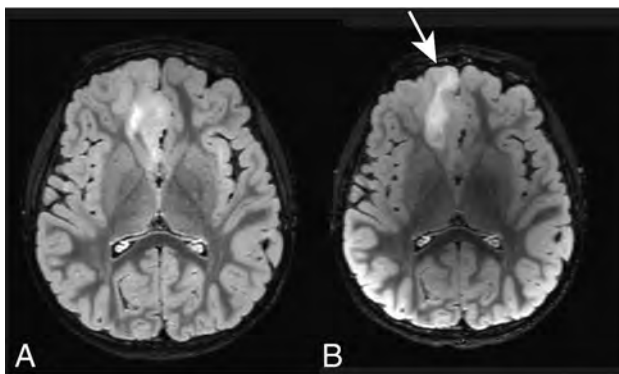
Axial FLAIR of a 4.5-year-old boy presenting with seizures. Initially, a focal cortical dysplasia of the right frontal lobe was proposed (A). The follow-up MR imaging 8 months later shows disease progression (arrow in B). After resection, the diagnosis of a CNS NB-FOXR2 was made, whereas the diagnosis of a focal cortical dysplasia was dismissed.
